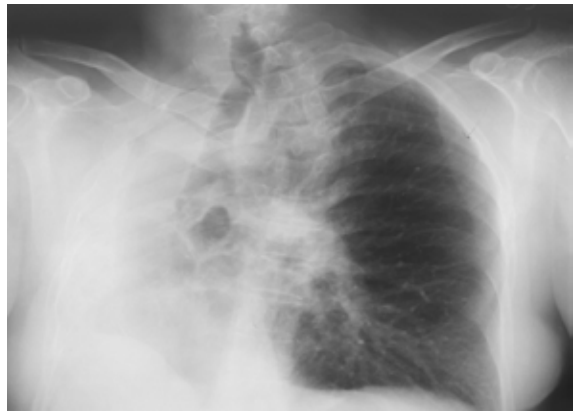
Chest X-ray showing a mat retracted right hemithorax with mediastinal shift to the right, left lung hyperinflation with lung haernia, upper tracheal stenosis, tracheomegaly, diaphragm raising and dextroconcave scoliosis
